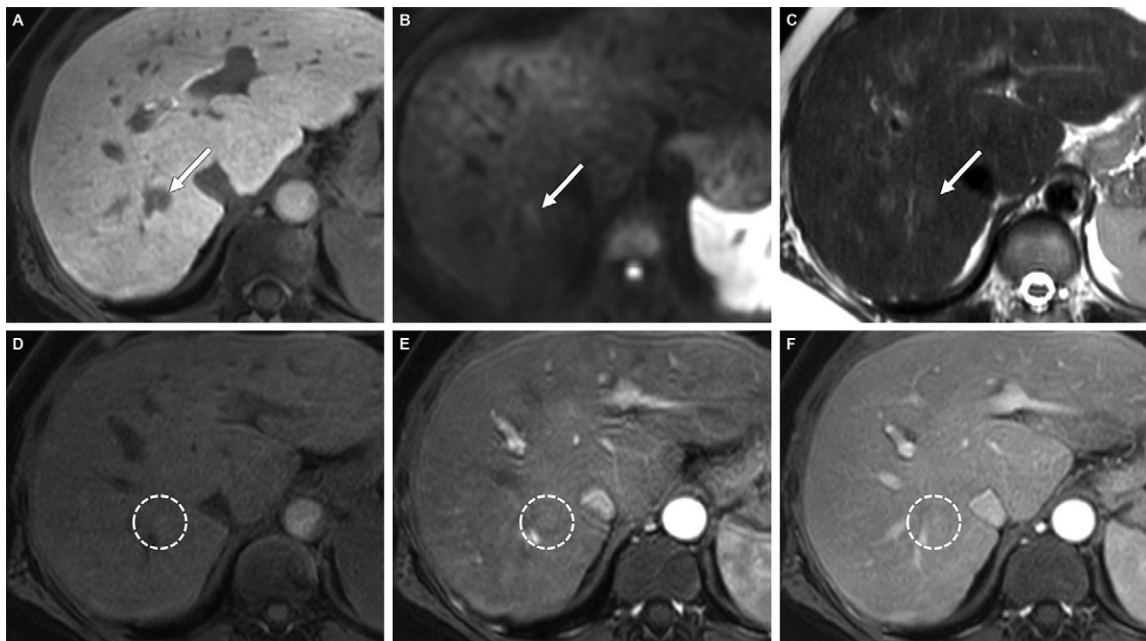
MRI scans with gadoxetate in a 57-year-old woman with hepatitis C virus cirrhosis. MRI scans demonstrate (A) a 10-mm observation (arrow) with hepatobiliary phase hypointensity, (B) mild diffusion restriction (arrow) with diffusion-weighted image with $b = 800 \text{ m/sec}^2$, and (C) mild T2-hyperintensity (arrow) with lesional fat sparing (not shown). The observation is not discernable on (D) precontrast T1-weighted image, (E) arterial phase, or (F) portal venous phase (the region of the observation is marked by a circle in D–F). The observation progressed to LR-5 (definite hepatocellular carcinoma) in 2 years.
